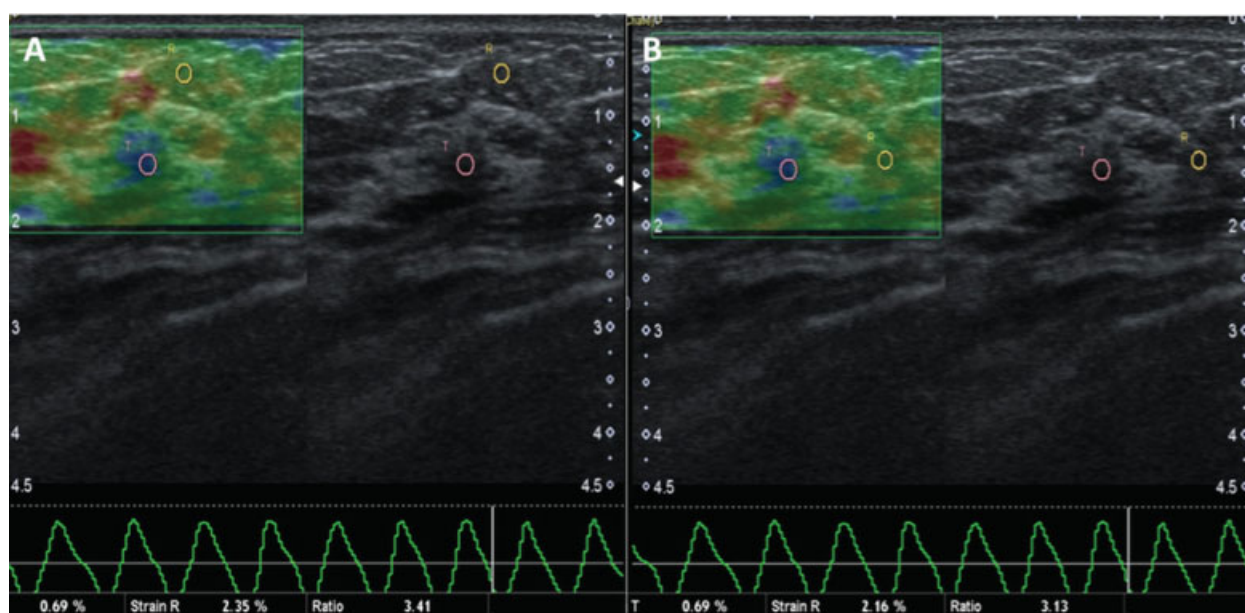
Example of elastography analysis, showing a conventional ultrasound image on the right and an elastography image on the left, used for the qualitative analysis. For the semi quantitative analysis, regions of interest (ROI) are positioned on the lesion and on subcutaneous tissue (A) or adjacent fibroglandular tissue (B).
